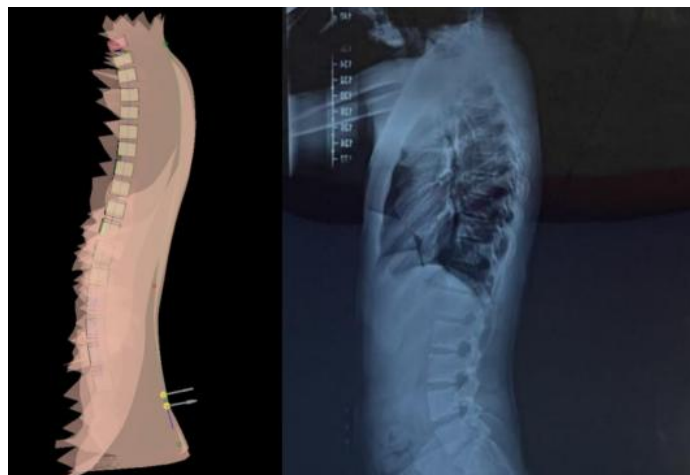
Comparative analysis of system outcomes and X-ray imaging in sagittal view.
